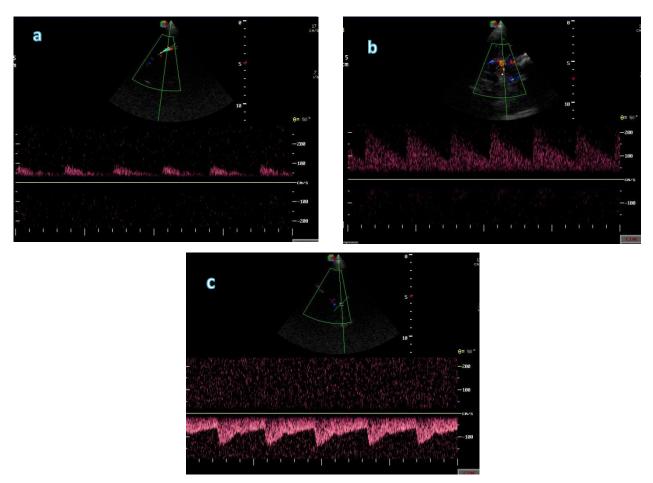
a) Spectral Doppler of MCA post trauma, demonstrated diastolic blunting secondary to raised intra-cranial pressure (pulsatility index = 3.14, PSV = 85 cm/sec). b) Further progression with change in baseline mean velocity of > 40 cm/s per 24 h demonstrating a mean MCA velocity of 125 cm/s (in-keeping with mild vasospasm). c) Following SGB interventions to reduce vasospasm, there was normalization of diastolic flow in the MCA, and resolution of high intracranial pressure (pulsatility index = 0.2, PSV = 97 cm/sec).
